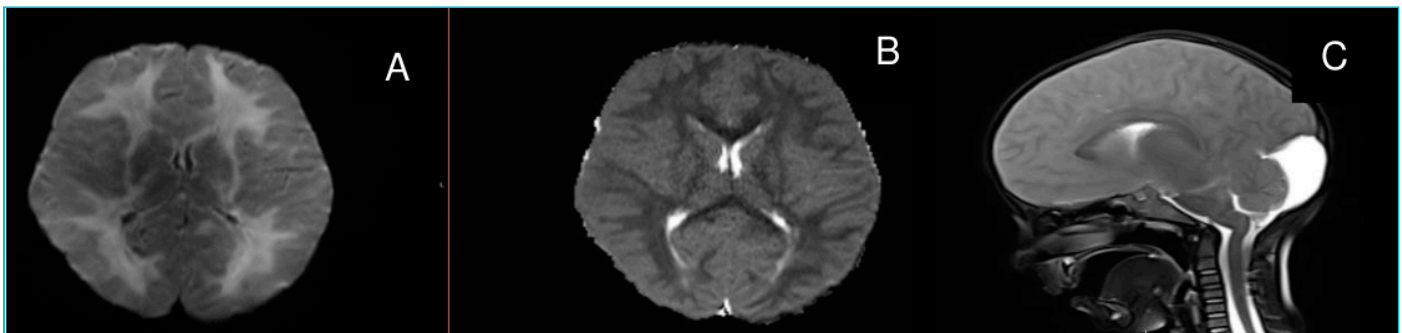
Diffusion (A, B) and sagittal T2 (C) magnetic resonance images of the patient
